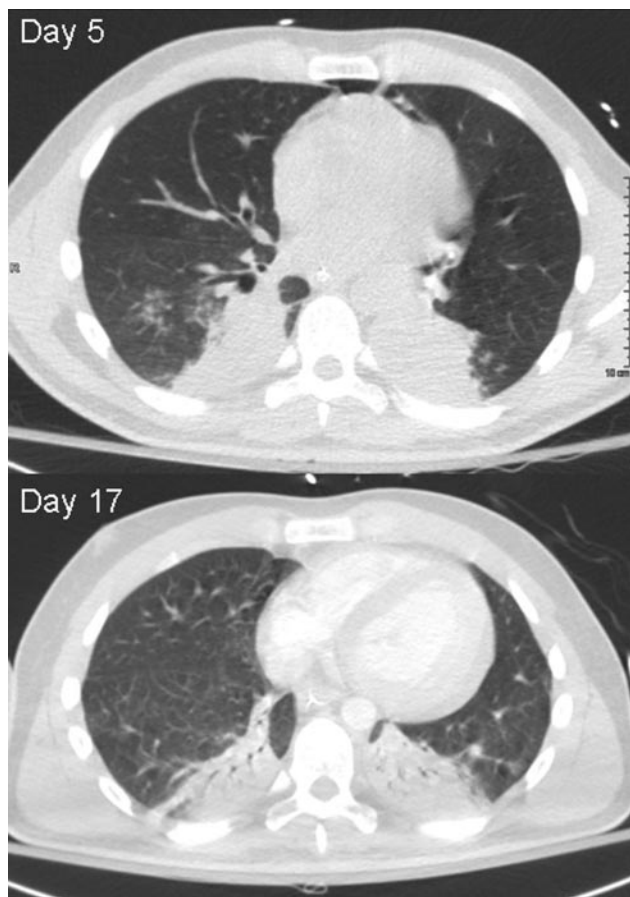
Lung computed tomogram showing consolidations in the dependent regions (day 5 and day 17).
